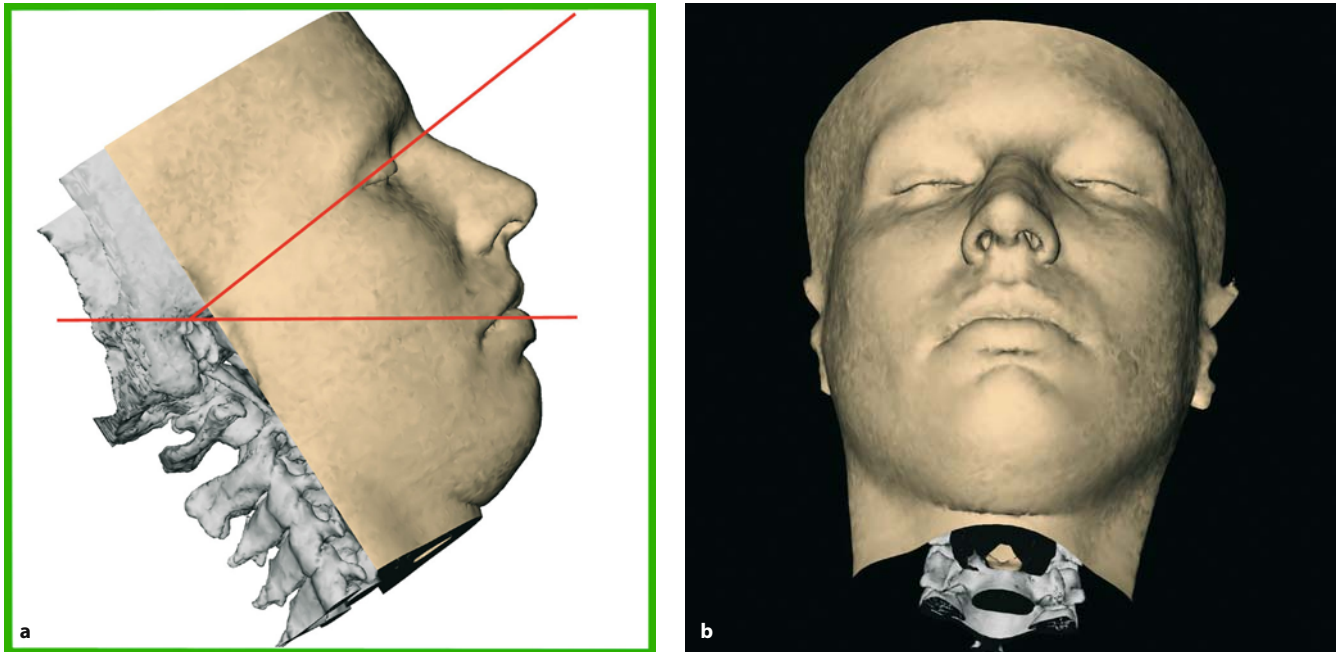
a,b. Modified Waters view (patient K.C.). In order to compute the virtual modified Waters X-ray, the skull is virtually positioned in the frontal view and posteriorly inclined until the cantho-meatal or trago-canthal line is 37° to the horizontal plane
